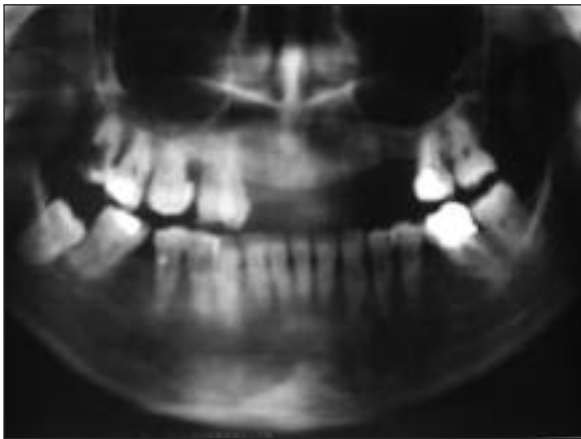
The radiographic view of the patient after one year treatment.
